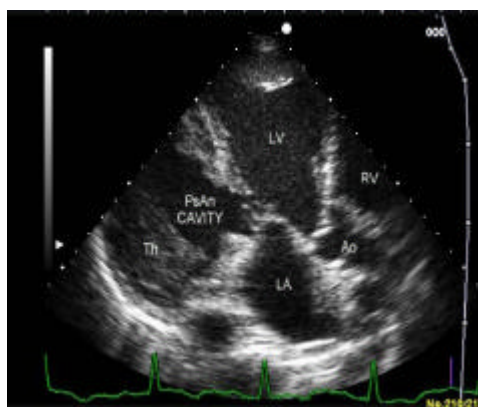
Transthoracic apical five chamber view of pseudoaneurysm of lateral wall of left ventricle with intramural thrombus
